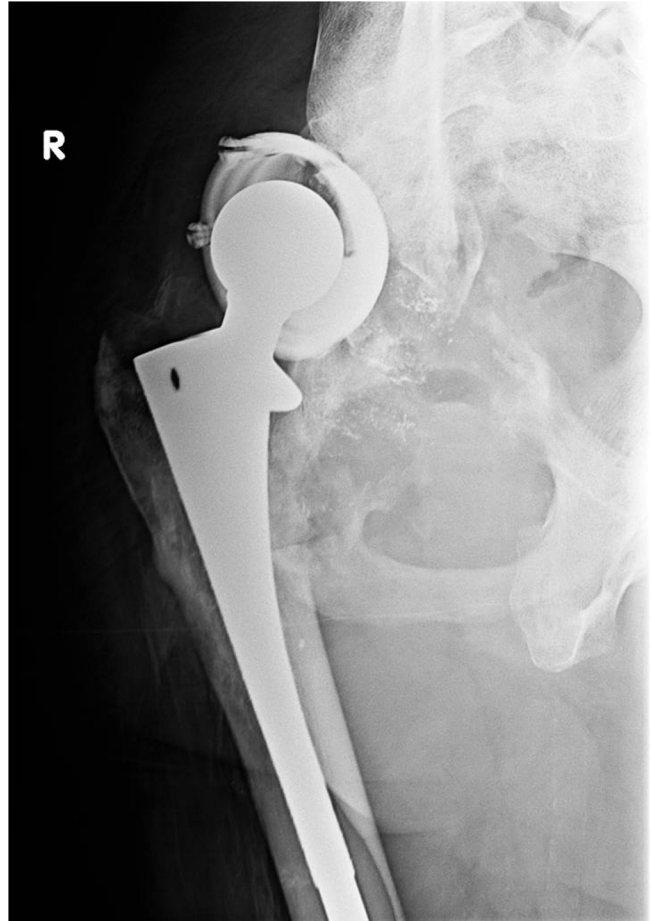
50-year-old man with extensive metallosis. Radiograph of the right hip shows further osteolysis of the greater and lesser trochanters and right acetabulum. A new fracture of the superior acetabular wall is present with superior migration of the femur. Small metallic particles are now seen on radiographs surrounding the hip prosthesis.
